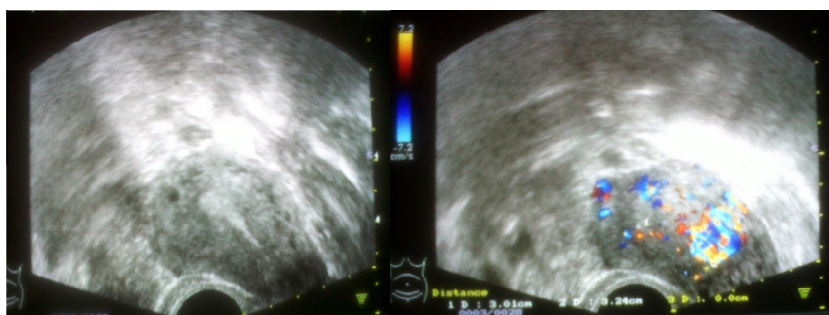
Transvaginal ultrasound showed an ill defined heterogeneous hyper echoic solid lesion with cystic areas seen in the myometrium away from the endometrium. Ultrasound also showed uterus with empty cavity (left) and vascular intramural mass with AVM (right).
